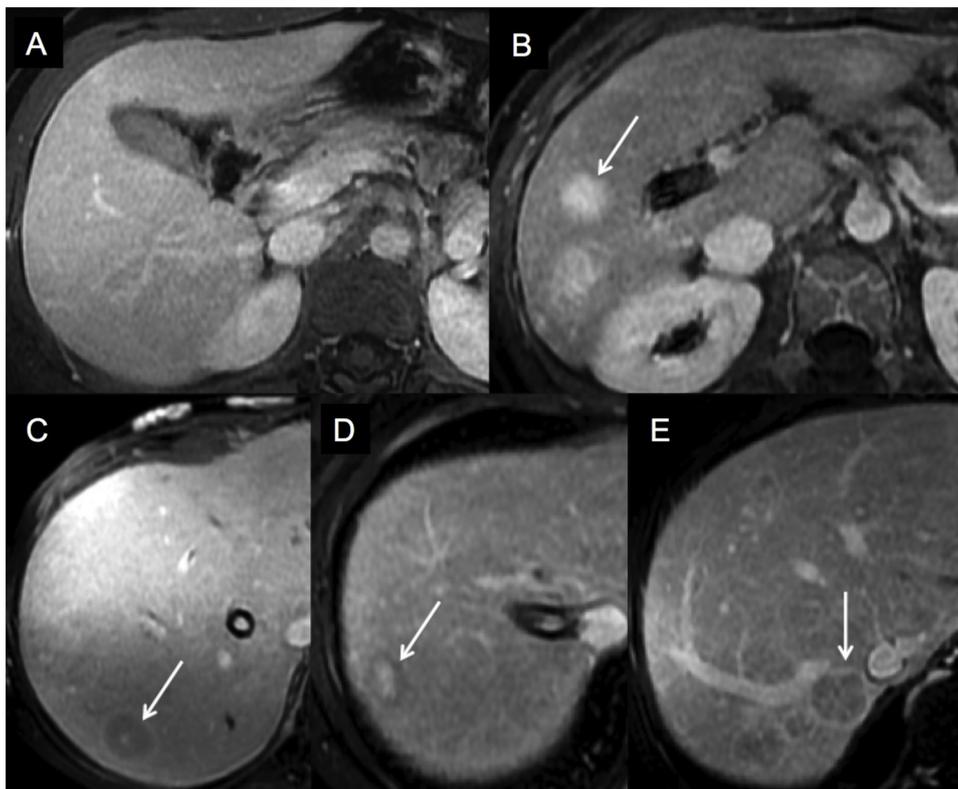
Late phase imaging. Delayed phase MRI (3–5 minutes) show that the lesions are usually isointense relative to the surrounding parenchyma (a) or slightly hyperintense (white arrow) (b). Some lesions can show wash-out mimicking hepatocellular carcinoma (HCC). These hypointense nodules can show a small (c) or large (d) hyperintense central scar (white arrows) and a slightly hyperintense peripheral rim (e) mimicking a capsule (white arrow).
